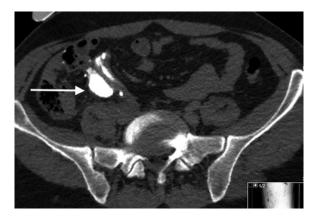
Urographic phase axial CT image demonstrates a contained leak of contrast at the site of the ileal conduit (arrow).
